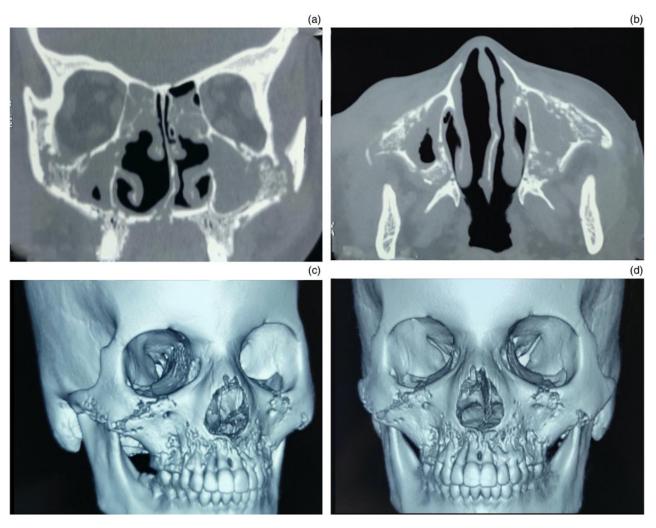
(a) Coronal and (b) axial two-dimensional, and (c & d) three-dimensional computed tomography images showing destruction of bilateral anterior and posterior walls of maxilla, with involvement of bilateral alveolus.
